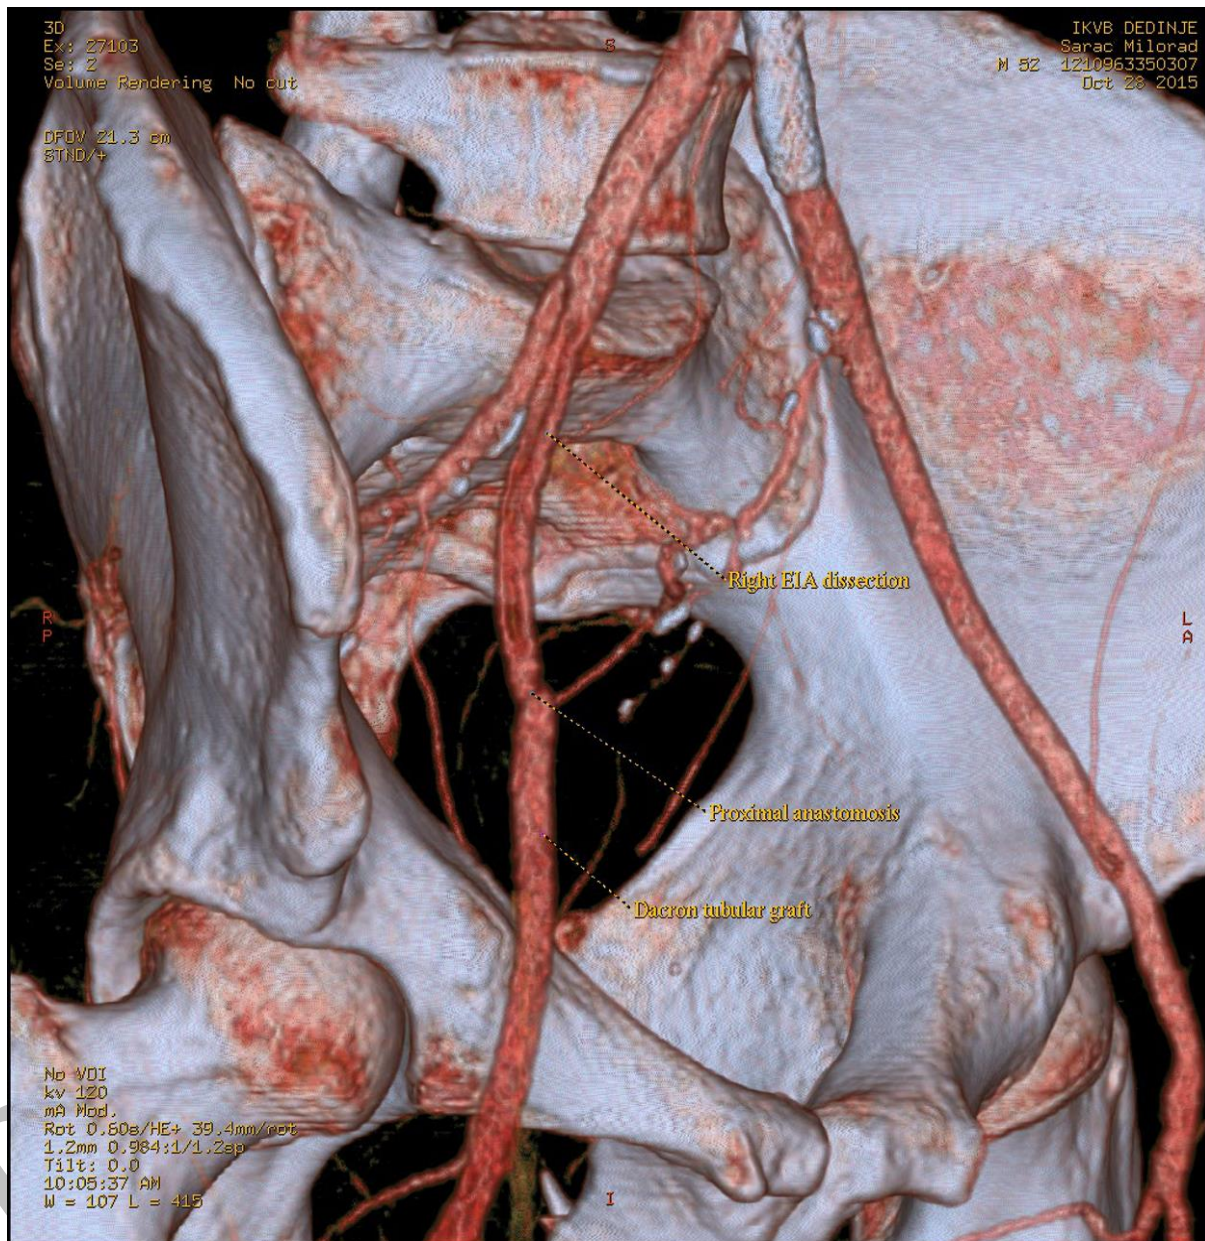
Multidetector computed tomography angiography; antegrade right external iliac artery (EIA) dissection starting just above proximal anastomosis of Dacron tubular graft
